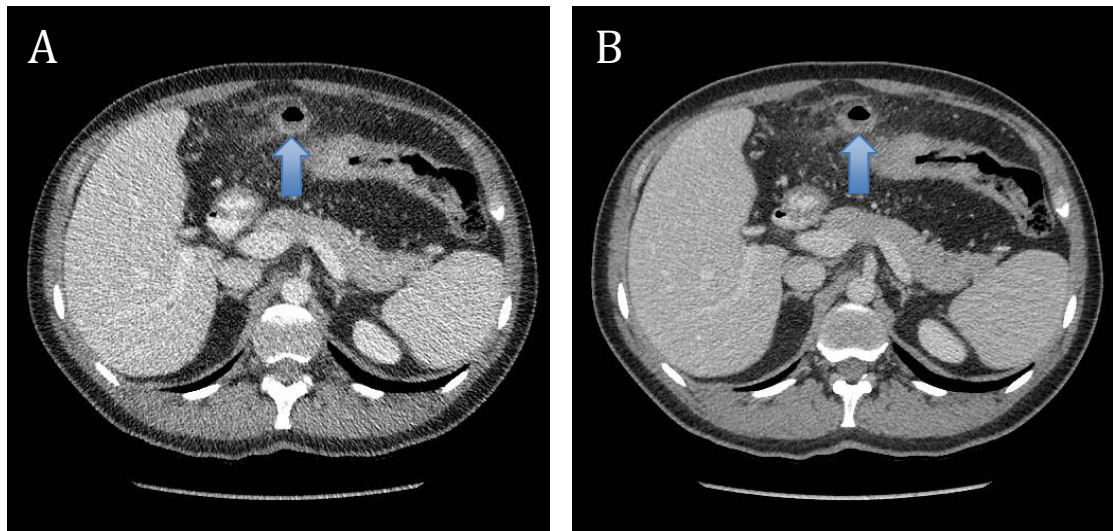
Modified (A) and conventional (B) dose axial CT reconstructions of the upper abdomen with blue arrows demonstrating a pericolic abscess in a 46-year old man with a BMI of 26.8kg/m². The effective doses of the modified and conventional dose acquisitions are 1.5mSv and 5mSv, respectively.
